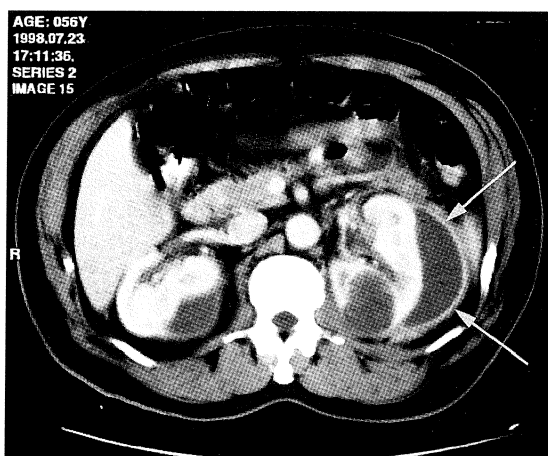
CT of the abdomen shows a left perinephric abscess, with prominent peripheral enhancement (arrows).
